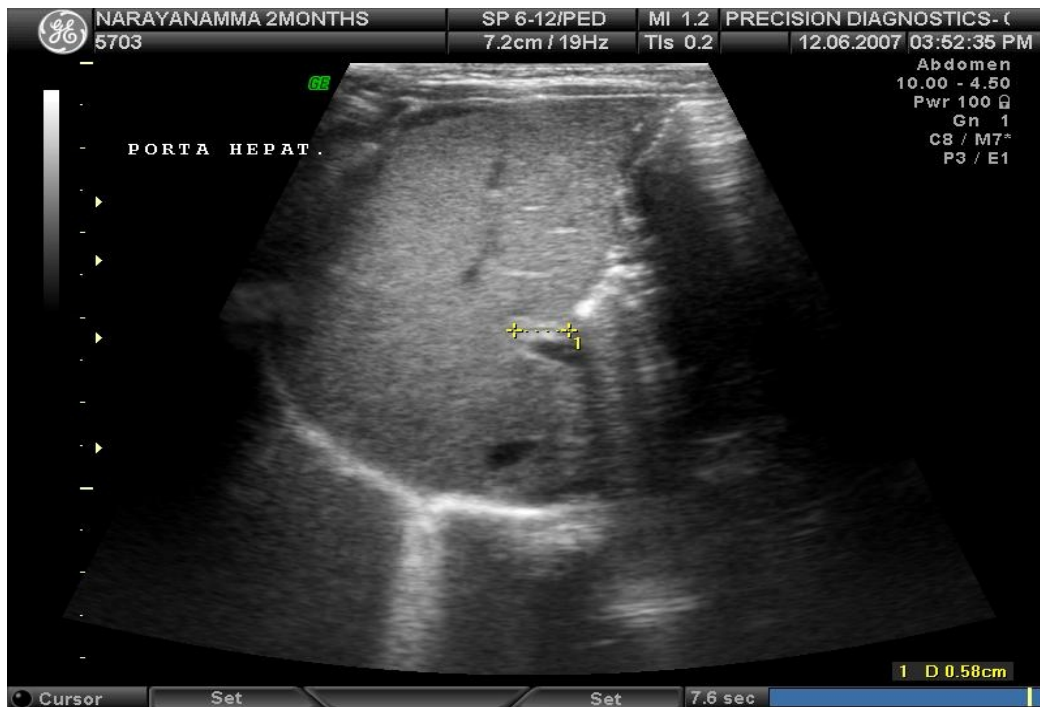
Ultrasonogram showing Triangular cord at porta hepatis
